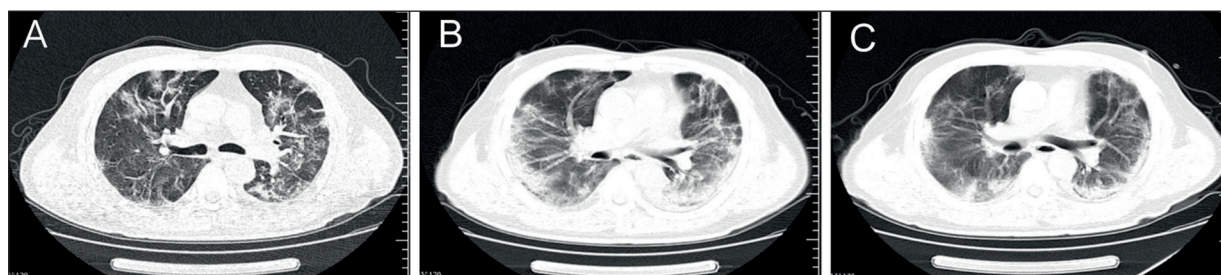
Chest CT images on day 5, day 12 and day 19 of hospitalization. A, Chest CT images on day 5 shows ground-glass opacities involving the subpleural regions of both lungs. B, Chest CT images on day 12 shows the range of ground-glass opacity extension. C, Chest CT images on day 19 shows the range of ground glass opacities assimilated in the bilateral lungs compared with that on day 12.
